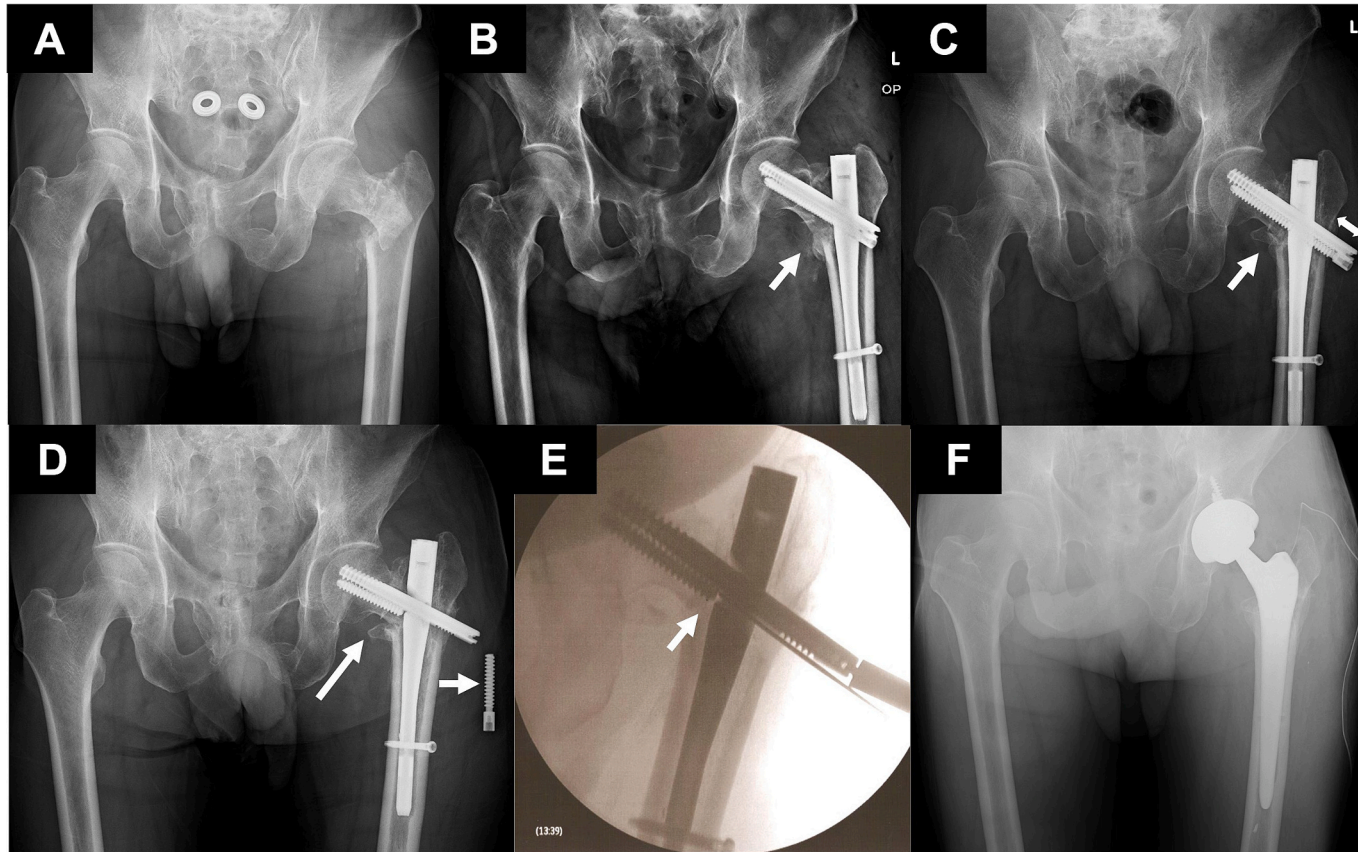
(A) Hip radiograph with a left femoral trochanteric fracture. (B) Immediate postoperative hip radiograph; the tip apex distance was 20.7 mm, and the medial cortical bone of the proximal femur was poorly repositioned with defects (white arrow). (C) Six-month postoperative hip radiograph showed lag screw telescoping by 21.5 mm (white double arrow) with nonunion (white arrow). (D) Nine-month postoperative hip radiograph showed breakage of the compression screw (short white arrow) with varus deformity of the fracture site (long white arrow). (E) Intraoperative fluoroscopic frontal view of the hip joint at the time of revision surgery. We could not insert an osteotome between the lag screw and the compression screw because no gap was present between the screws (white arrow). (F) Hip radiograph immediately after revision THA. Good positioning of the implant was achieved.
